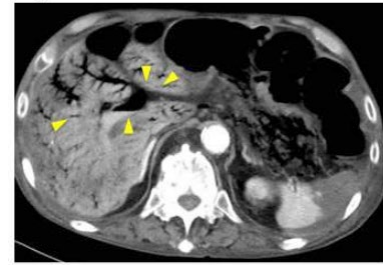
Axial section of abdominal computed tomography (CT) showed a massive amount of hepatic portal venous gas (arrows) and extensive intestinal ischemia.
